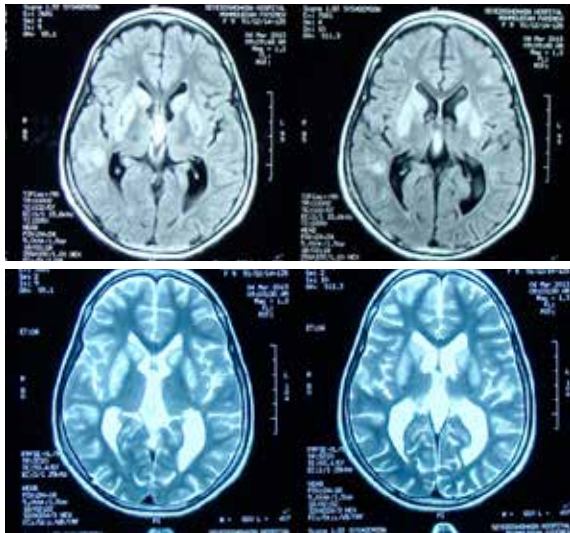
Bilateral symmetric lesions of the caudate nucleus and the putamen in brain MRI
